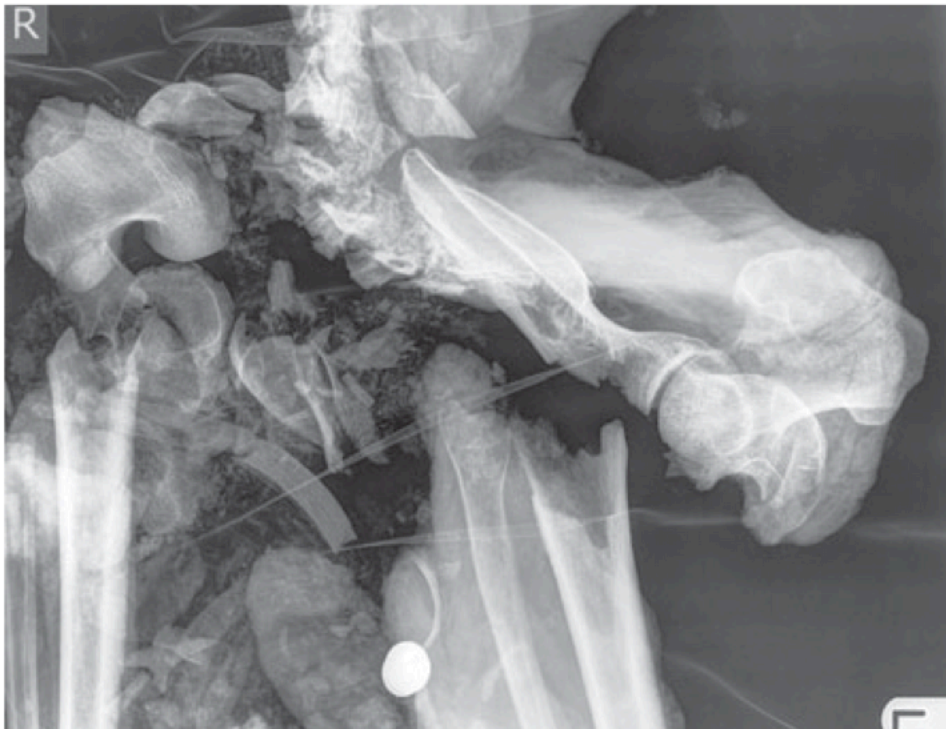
Radiography of charred remains is recommended in order to look for projectiles. These fragmented burnt remains include part of a disposable lighter.
